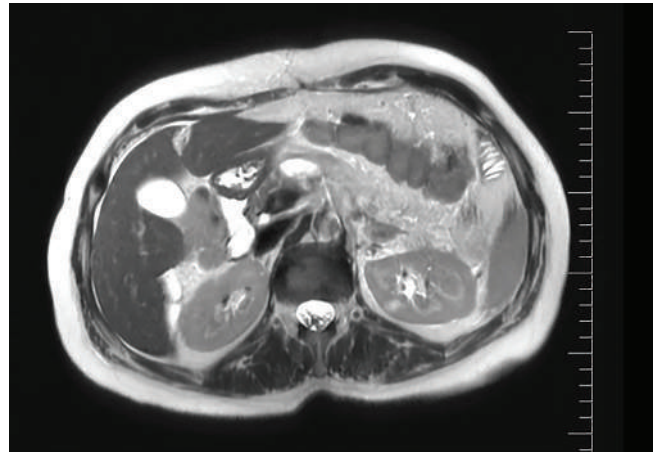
Magnetic resonance imaging sections. A 24×8 mm fluid-density area is present anterior to the head of the pancreas. In the tail region, a 5×3 cm fluid collection, considered secondary to prior surgery, is observed.
